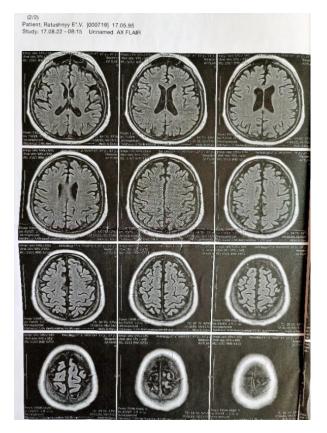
Brain MRI of the patient with 15q11.2 microduplication syndrome. Local leukoaraiosis in the area of the frontal horn of the right lateral ventricle. Hypotrophic changes in the cortex in the area of the frontal lobes of the brain.
